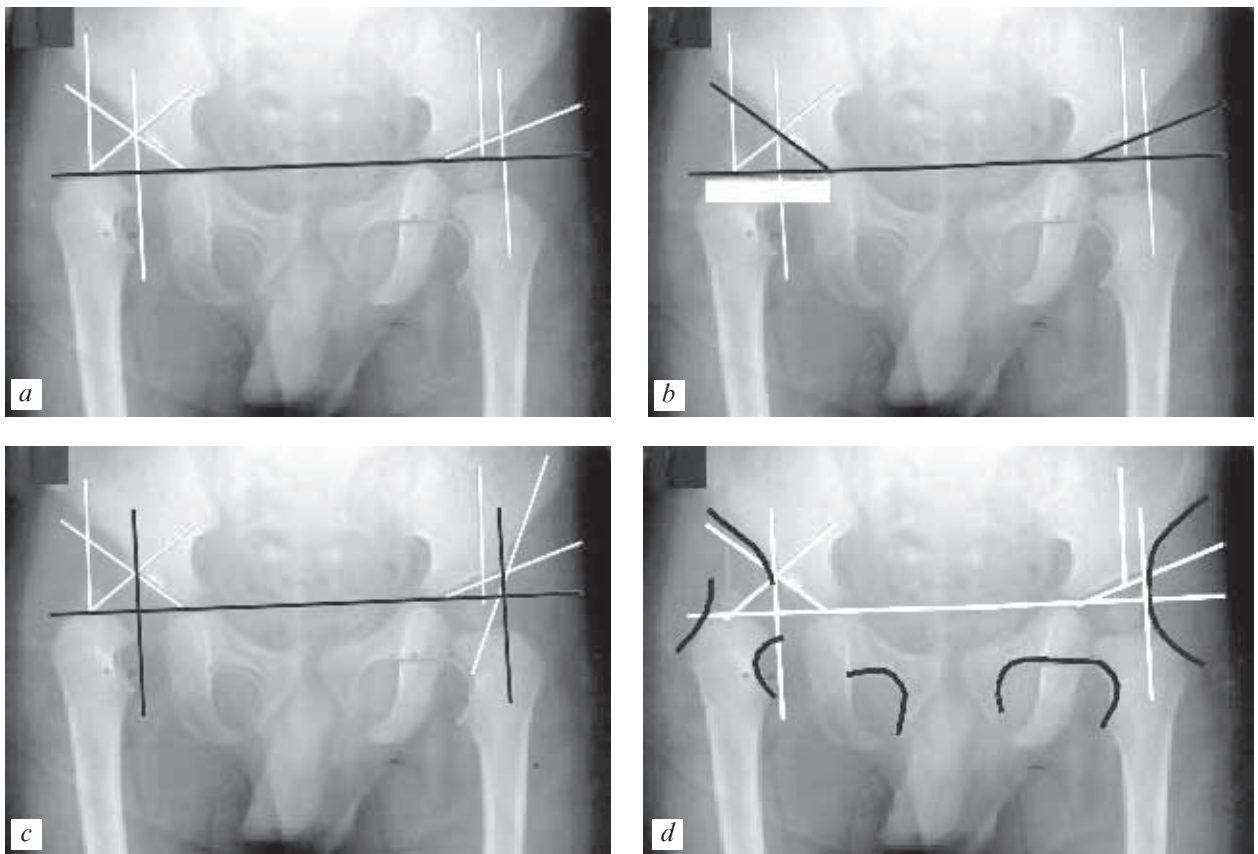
Roentgen study (a-d)
